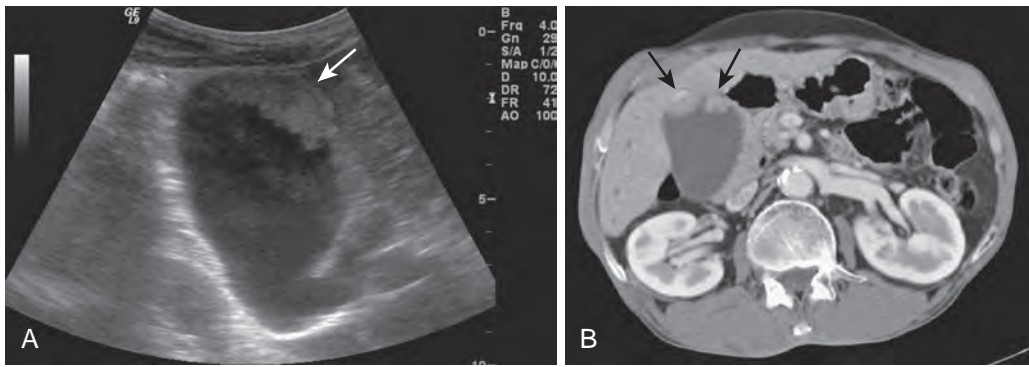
Gallbladder adenoma. A. Sonogram shows a sessile polypoid mass (arrow). B. CT scan demonstrates an enhancing polypoid gallbladder adenoma (arrows).
